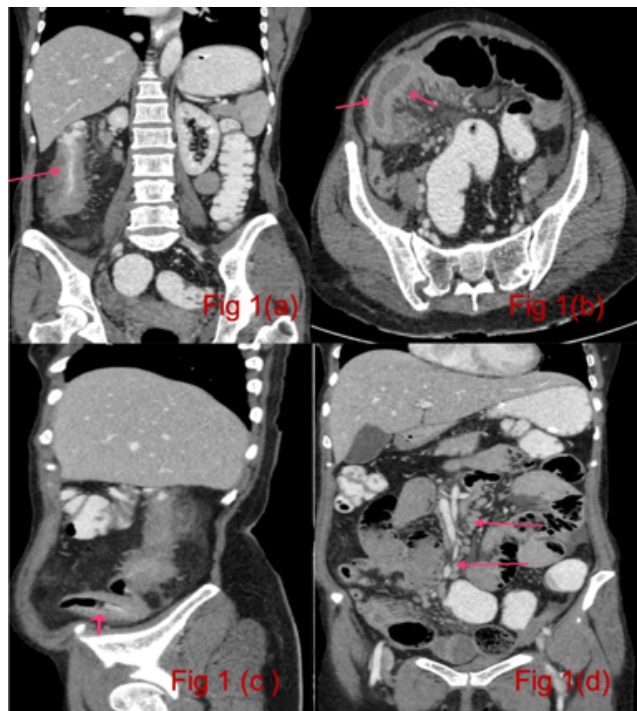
a: Post contrast coronal reformatted image - circumferential wall thickening of 17 mm with luminal narrowing noted in right colon and caecum. Thickened wall shows near homogenous symmetric transmural enhancement; b: Axial post contrast CT images showing Proximal ileum- seen beneath the anterior abdominal wall in right iliac fossa extending over length of 60 mm, transmural, mural wall thickening (10 mm) showing homogenous symmetrical transmural enhancements and stratified mural hyperenhancement causing luminal narrowing. Prominent vasa recta and ill-defined soft tissue infiltrates in vicinity; c: Sagittal post contrast Images -Terminal ileum-extending over a length of 42 mm, circumferential wall thickening (10 mm) showing homogeneous symmetrical transmural enhancement causing luminal narrowing; d: Multiple prominent mesenteric Lymph nodes with mild free fluid.
